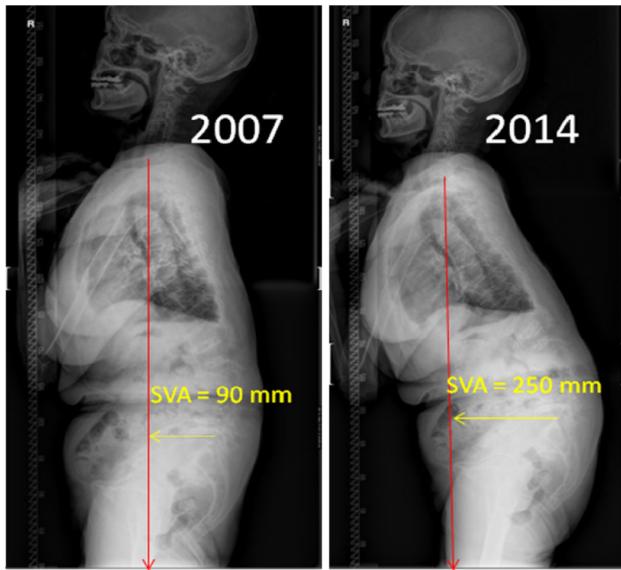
The comparison of the progressive sagittal imbalance from the long standing radiographic images between year 2007 and 2014 (SVA sagittal vertebral axis)
